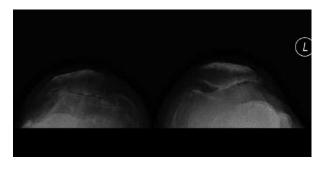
(a-c): Preoperative AP (a), lateral (b), and Merchant (c) radiographs demonstrating end-stage tricompartmental osteoarthritis.
